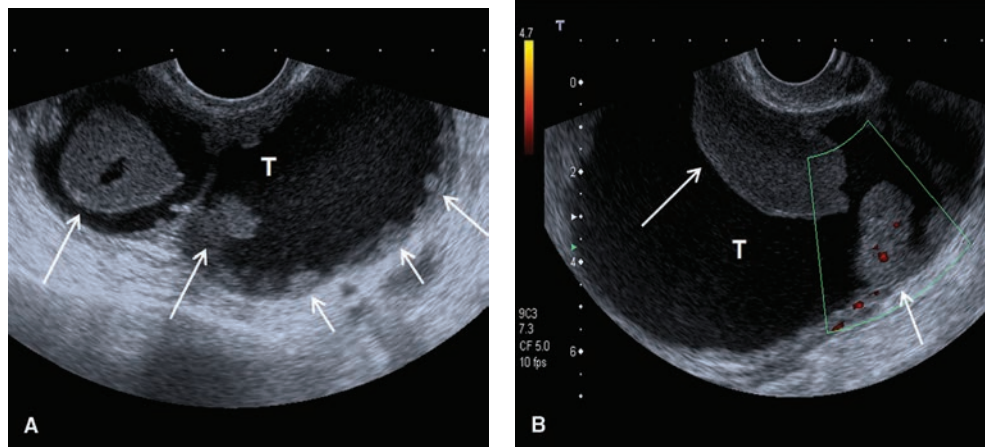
Ovarian carcinoma. Gray scale TVS image (A) and color Doppler TVS image (B) demonstrate a complex adnexal mass (T in A, B). Note the presence of multiple soft tissue components in the wall of the mass (white arrows in a, b). Increased blood flow is seen in the soft tissue components on the color Doppler image.
